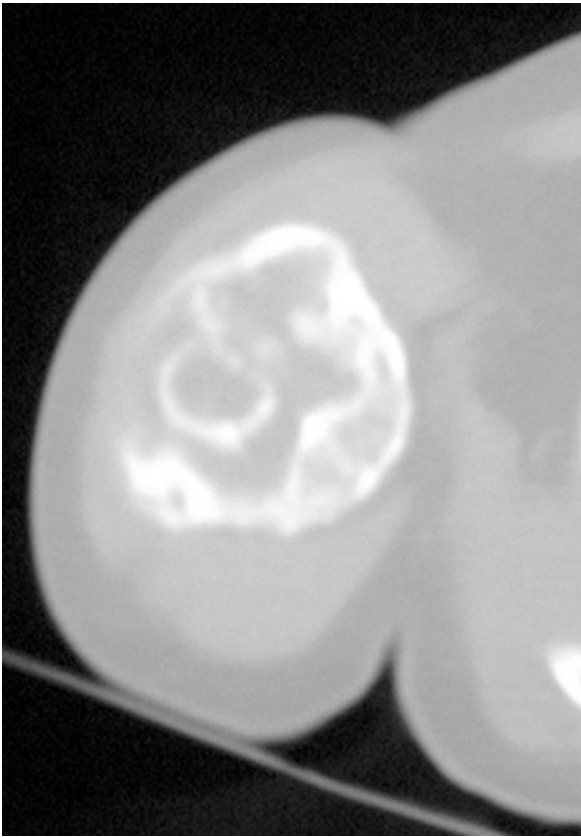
Post-chemotherapy CT
